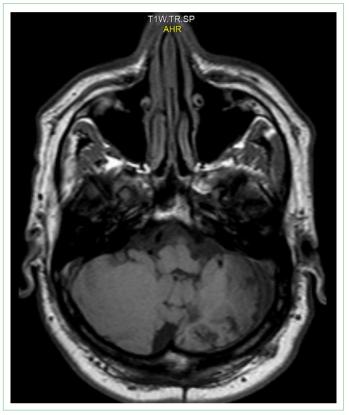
Control MRI one year after M.Y.in surgery.
